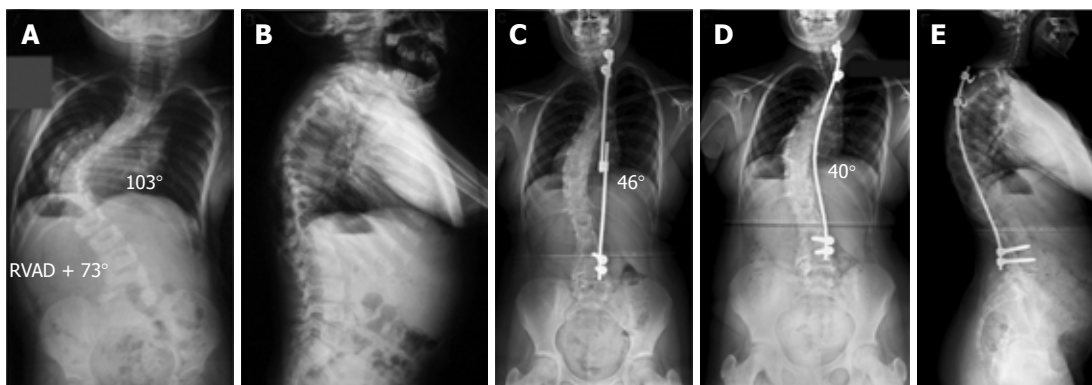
Patient with a severe infantile idiopathic thoracic scoliosis. A: Initial postero-anterior spinal radiograph at age 2 years shows a very severe thoracic scoliosis; B: Initial lateral spinal radiograph at age 2 years shows increased thoracic kyphosis. The patient was treated with placement of a concave growing rod construct followed by 21 consecutive lengthening procedures; C: Postero-anterior spinal radiograph at age 13 years when she underwent the definitive posterior spinal fusion with the use of a single concave rod construct; D: Postero-anterior spinal radiograph at latest follow-up (end of spinal growth) shows no evidence of recurrence of the deformity and no crankshaft effect with a globally balanced spine; E: Lateral spinal radiograph shows good global balance in the sagittal plane at skeletal maturity.
